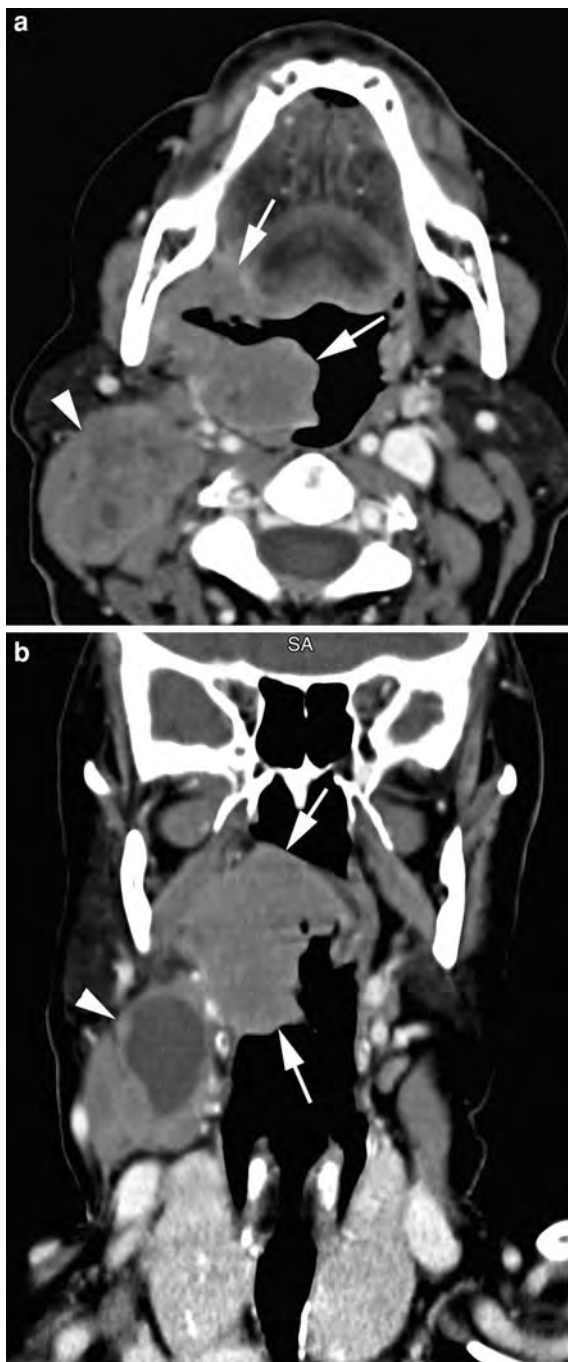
Tonsillar NHL. Contrast-enhanced multislice CT-images. a Axial contrast-enhanced CT shows a soft-tissue mass situated in the right tonsil (arrows). There is anterior extension (within the pharyngeal wall) along the glossotonsillar sulcus with slight displacement of the right tongue base. A grossly enlarged lymph node is present in level II (arrowhead). b Coronal reformatting shows the medial extension of the mass (arrows) with involvement of the soft palate. The level II lymph node contains a large area of central necrosis (arrowhead) (Courtesy R. Hermans, MD, PhD, Leuven, Belgium)
